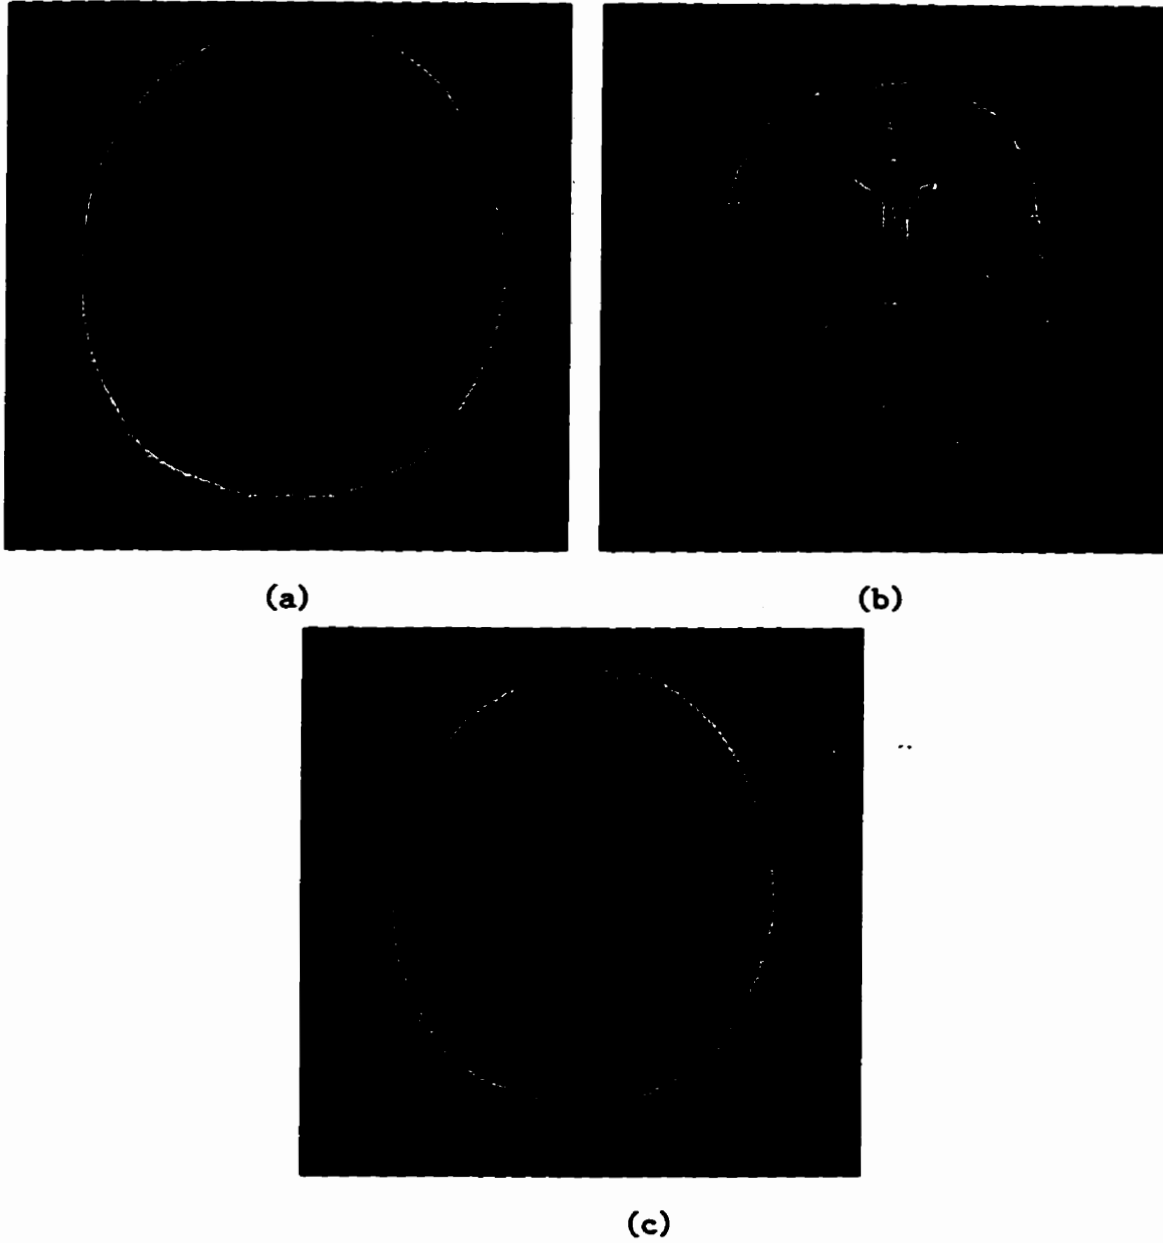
(a): A T1-weighted image (b) A T2-weighted image (c) A PD-weighted image.
